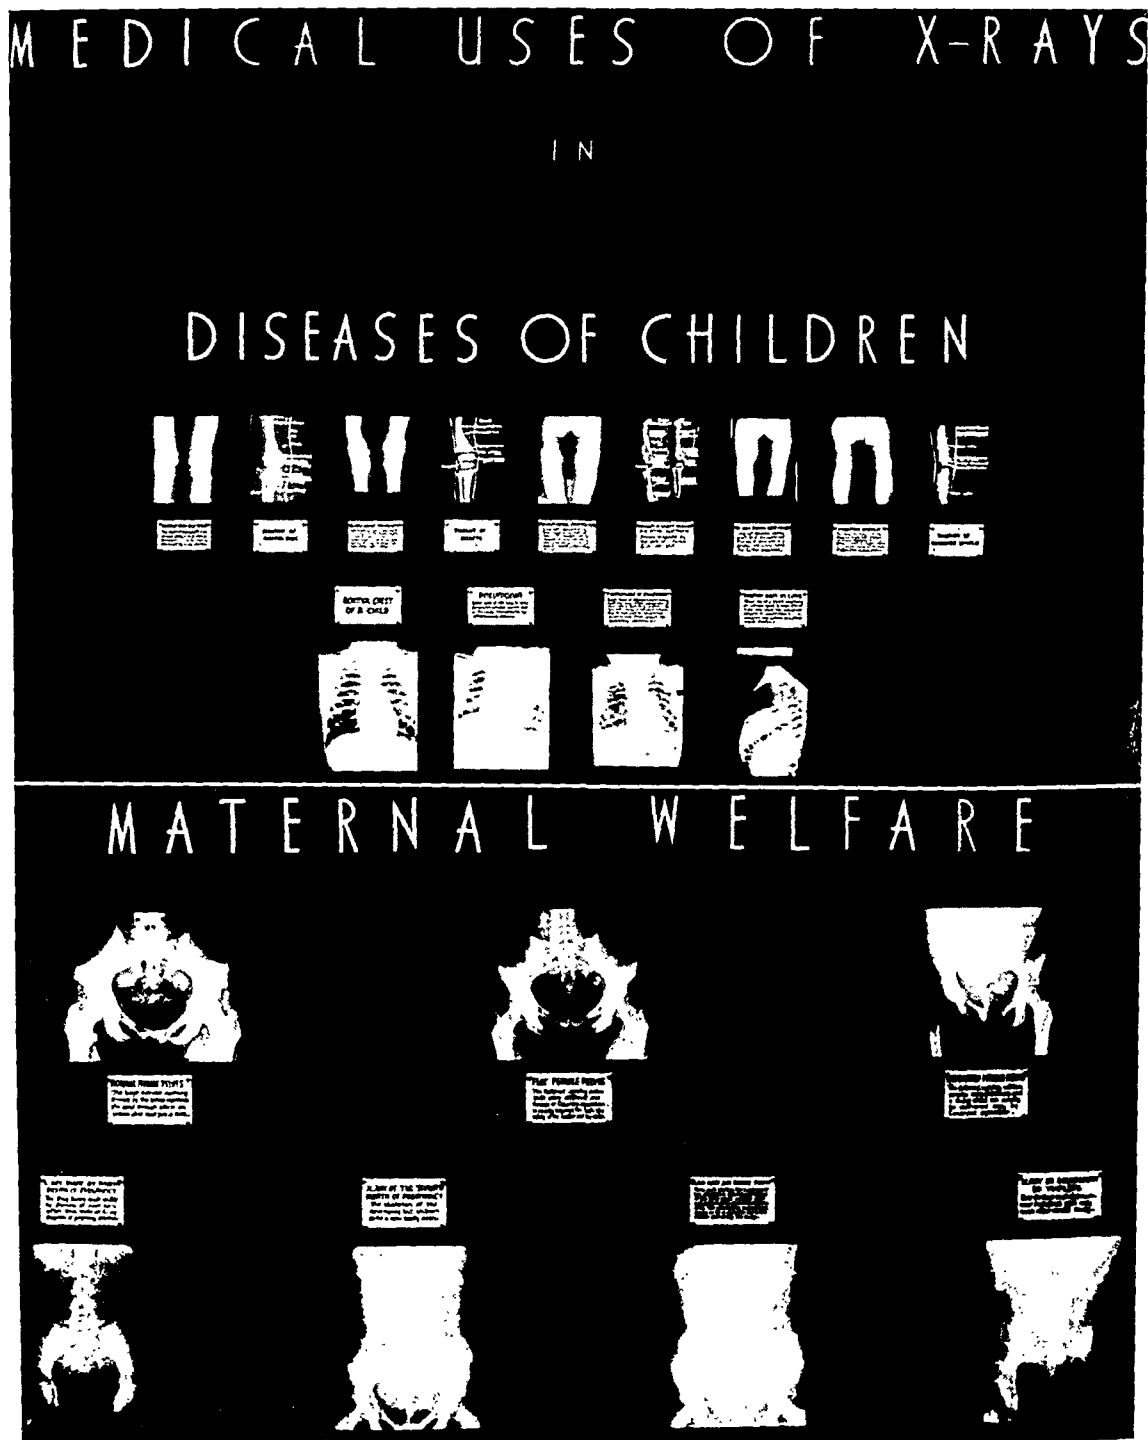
(above). Portion of the panel showing uses of x-rays in diseases of children.
